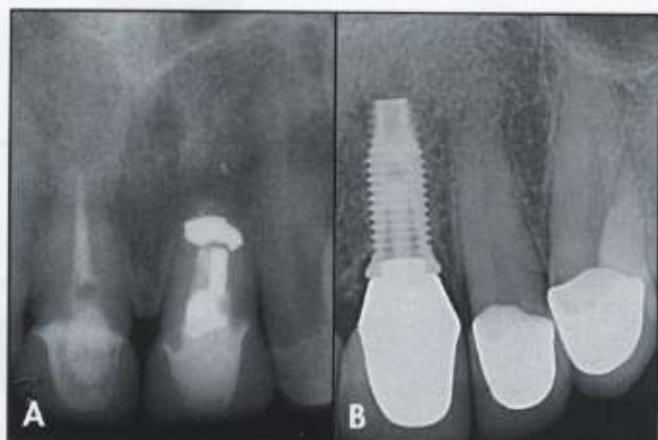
Preoperative radiograph of the anterior maxilla.
